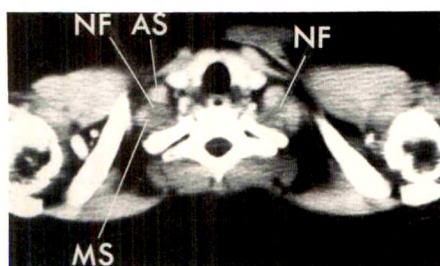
26-year-old woman with neurofibromatosis. CT scan shows bilateral enlargement of brachial plexus with splaying of anterior and middle scalene muscles by neurofibromas.
